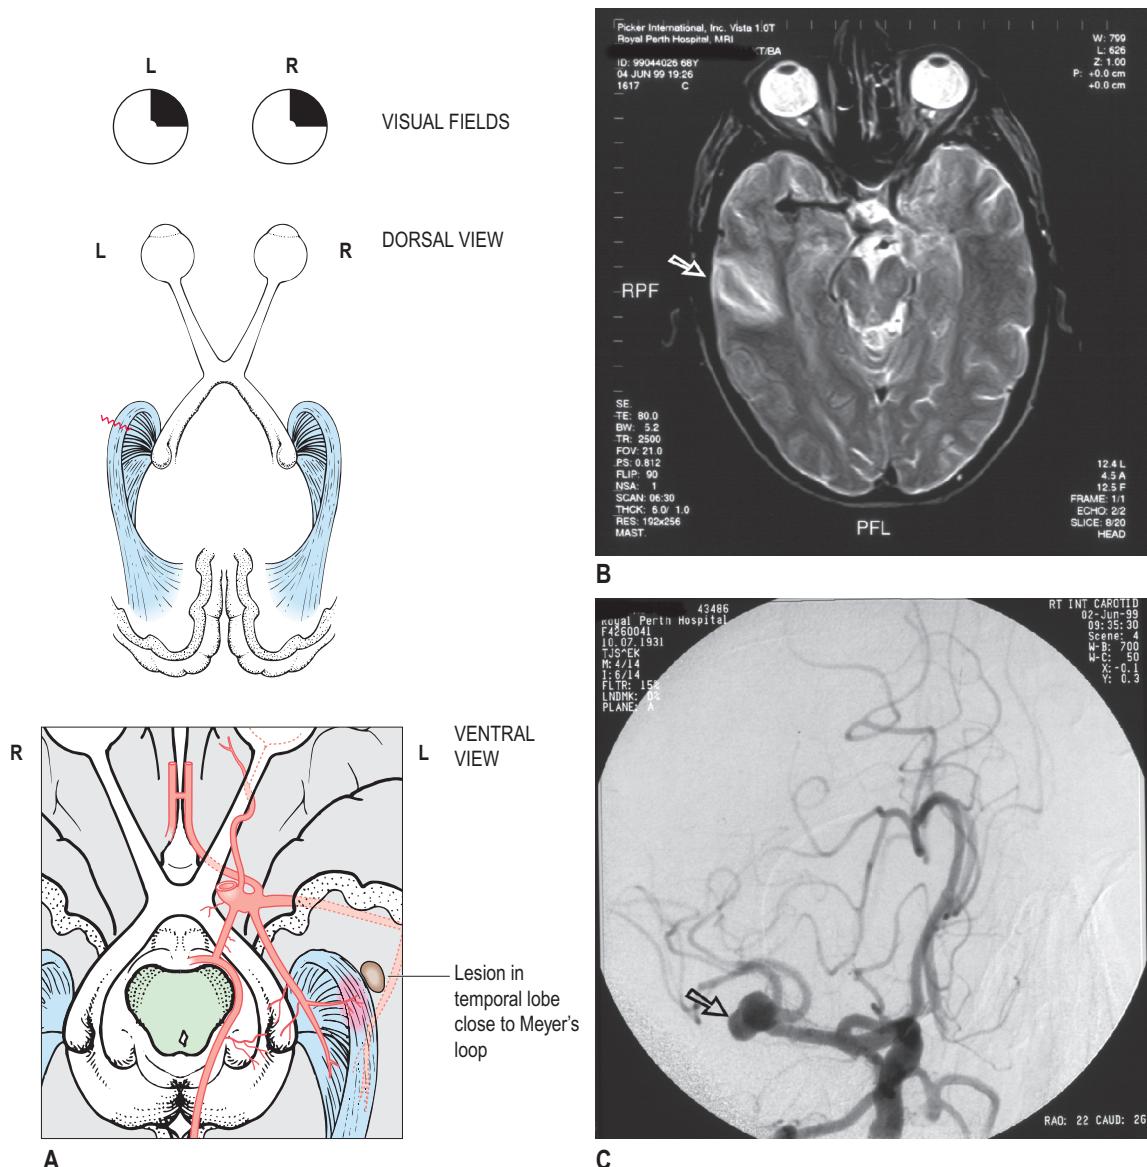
(A) Contralateral homonymous superior quadrantanopia (top panel) – so called ‘pie in the sky’ defects – may result from lesions in the temporal lobe affecting the fibres furthest into the optic radiation (middle panel) (see Fig. 1-68B), which are derived from the inferior retinal quadrants and therefore cause deficits in the superior visual field. (B) Radiographic image of the brain of a 68-year-old patient with a stroke in the right middle cerebral artery (MCA) territory. Axial MR scan (diffusion weighted) shows the size and limits of the right temporo-parietal infarct (arrow). (C) The digital subtraction carotid arteriogram (anteroposterior projection) shows the aneurysm (arrowhead) at the bifurcation of the right MCA. The extent of the ischaemic changes in the temporal lobe (involving the optic radiation) are consistent with the patient’s loss of the left visual field causing him to bump into objects. (Radiographic images courtesy of Prof. T. Chakera, Royal Perth Hospital.)
